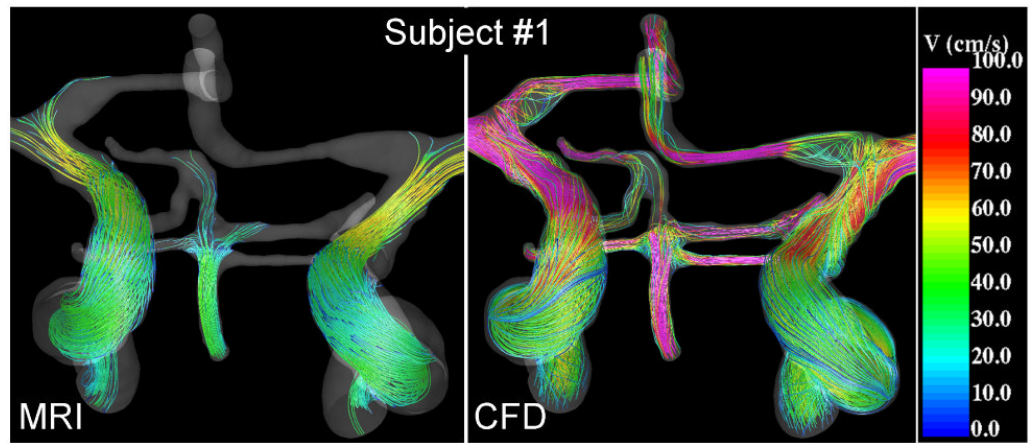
Visualizations of the blood flow patterns at peak systole in the major cerebral arteries of subject #1 obtained from the MRI (phase-contrast MR) data and CFD model.
